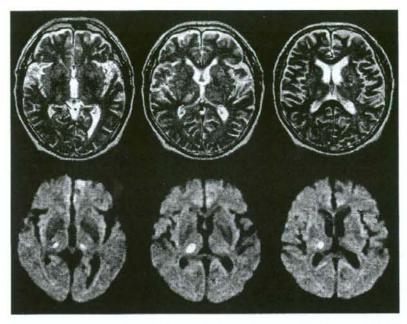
MRI T2-weighted images (upper images, TR/TE = 4000/120 ms) and diffusion-weighted images (lower images, TR/TE = 3800/96, b = 1000 s/mm²) obtained with a 1.5T Signa EXCIT HD system (GE Medical Systems, Milwaukee, Wis) showed bilateral hyperintensity in the thalami. Three-dimensional reconstruction using the Schaltenbrand and Wahren atlas (see Ref. [7]) showed that the lesions were located in the right ventral posterior and ventral lateral nuclei and the left dorsomedial nucleus.
